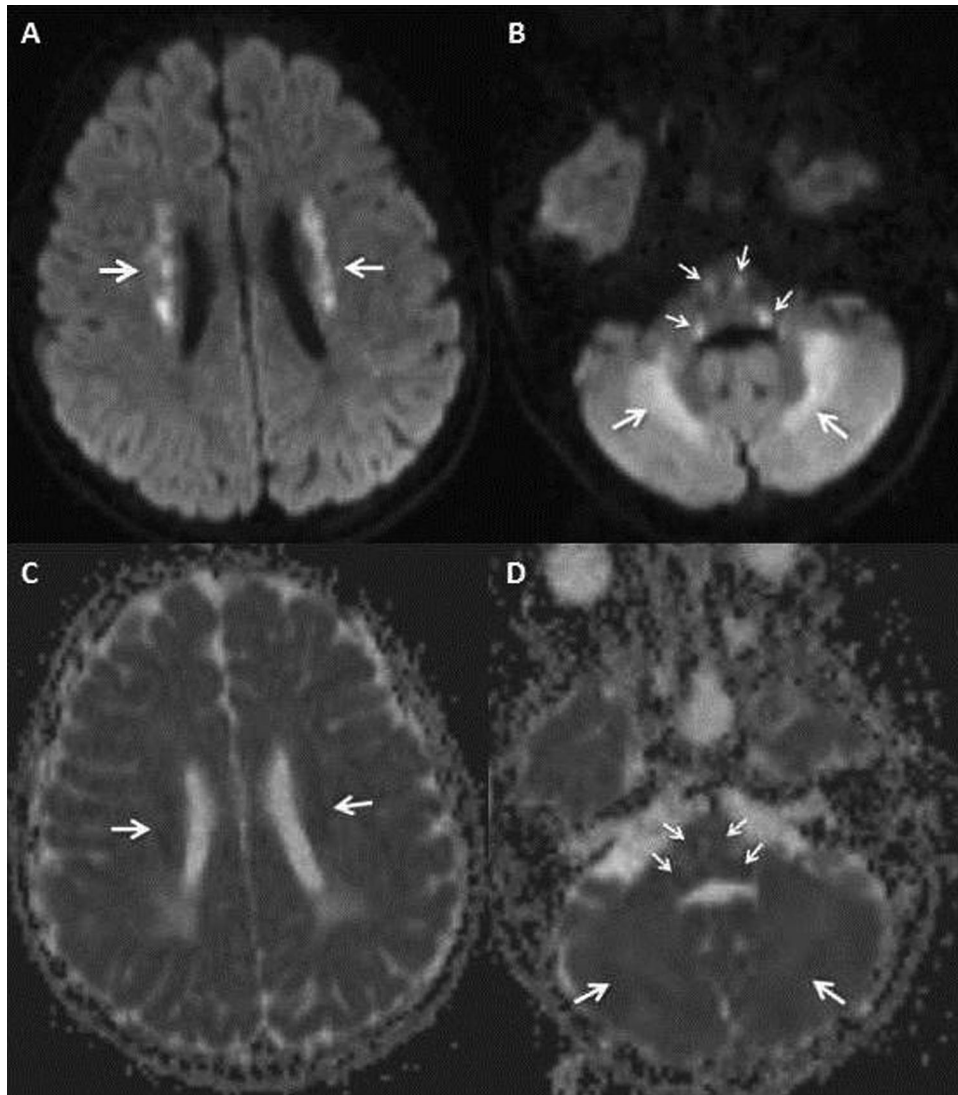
DWI shows symmetric diffusion restriction in corona radiata (A, C) and cerebellar deep white matter, ascending and descending tracts of brain stem (B, D).
